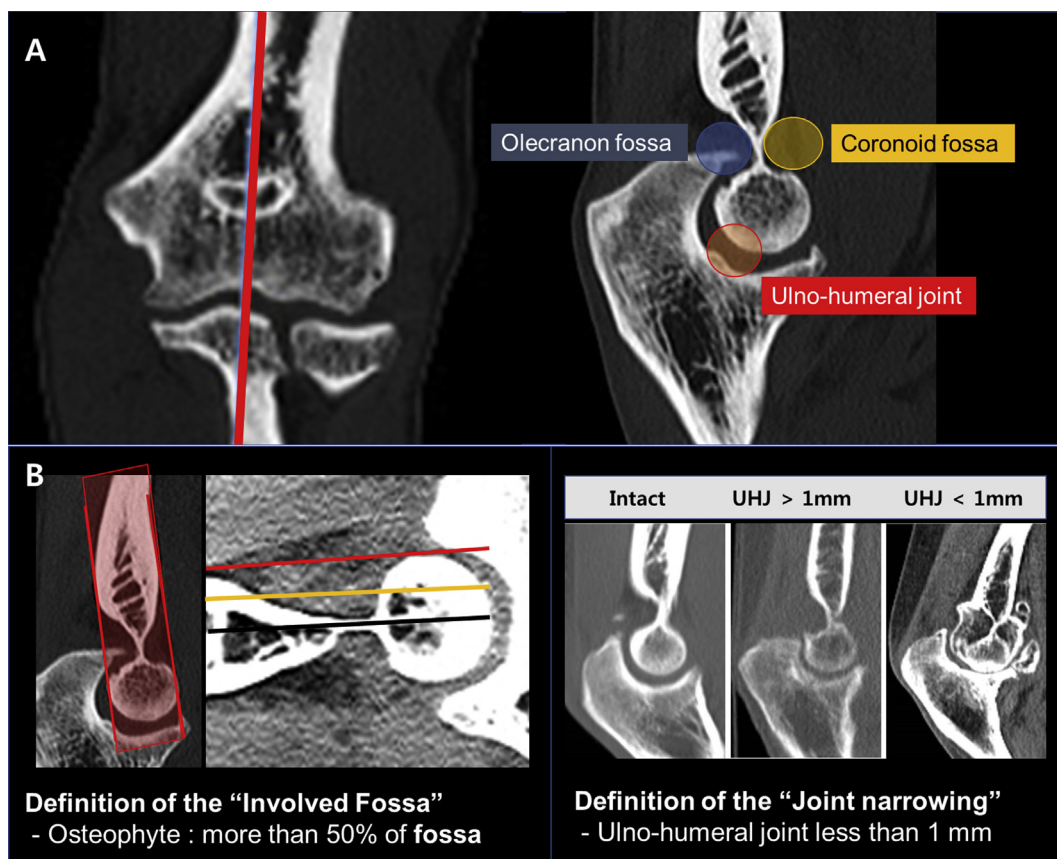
(A) Reference section for computed tomography (CT) based Classification for elbow primary OA. The center of fossas as reference section (Left). Spur in the coronoid and olecranon fossa is related with limitation of flexion and extension. Joint narrowing is related with resting or mid arc pain clinically (Right). (B) Definition of the "Involved fossa" (Left) and "Joint narrowing" (Right).
